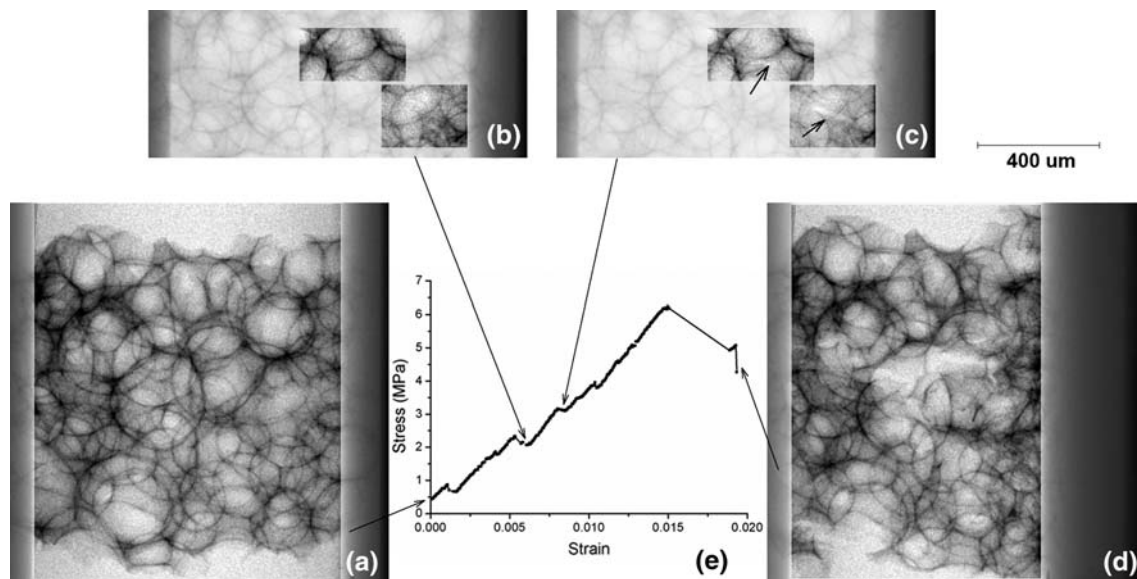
a–d Transmission μ CT images of a bioactive glass scaffold undergoing compression during in situ compression testing inside a laboratory based μ CT machine and e the stress–strain curve obtained
